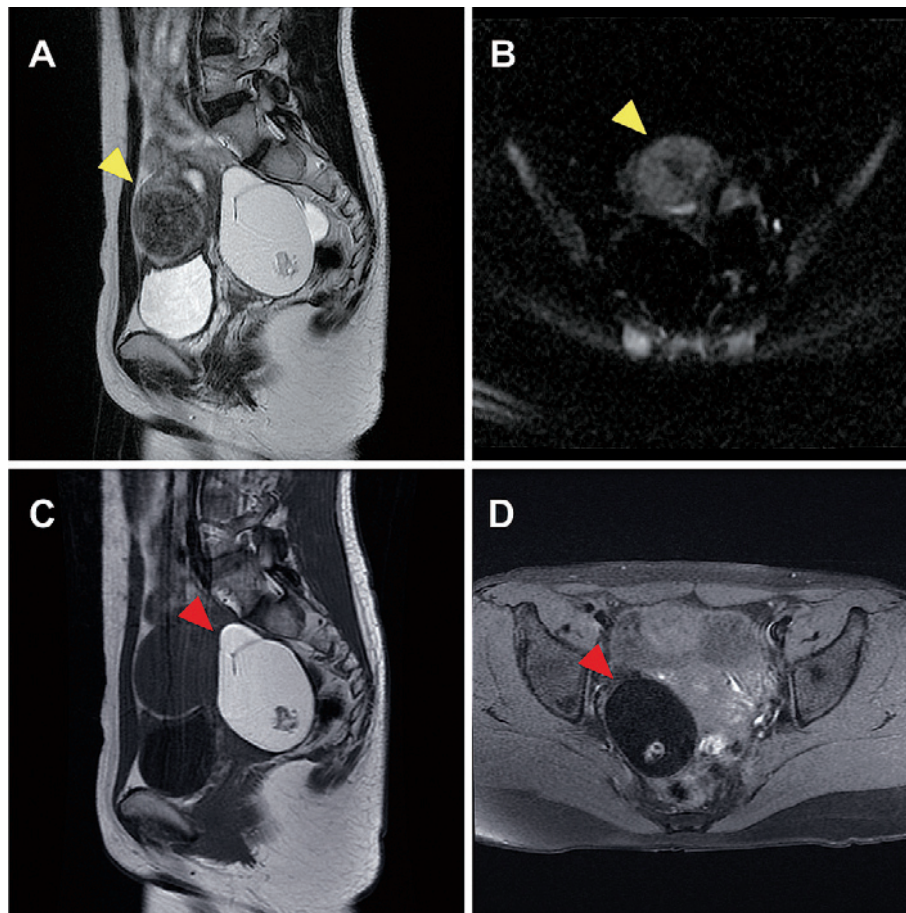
Magnetic resonance imaging features of uterine adenomatoid tumors. A 5-cm well-circumscribed mass can be observed in the anterior uterine wall (yellow arrowhead), with hypo-intensity on both T2WI (A) and DWI (B), and less Gd enhancement, compared to the normal myometrium (A). An 8-cm right ovarian cyst (red arrowhead) showing hyper-intensity on T1WI (C), and extreme hypo-intensity with fat suppression (D).
